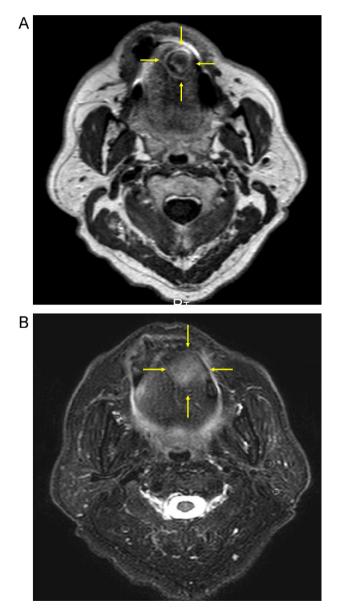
Axial enhanced magnetic resonance T1-weighted image revealing a relatively well-circumscribed rounded mass with heterogeneous hypointensity in the left tongue region (A). T2-weighted image showing the tumor to have hyperintensity (B). The mass was $20 \text{ mm} \times 20 \text{ mm} \times 18 \text{ mm}$ in size (arrows).
